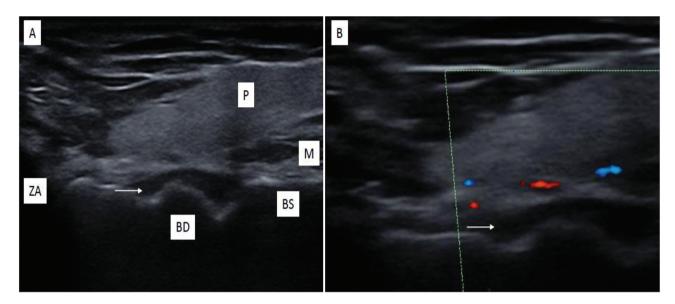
Ultrasound image of the right cheek region (cropped images). Cranial is to the left in both figures. (A) The overview shows the parotid gland (P) with the masseter muscle (M) below. The complete reflection of the ultrasound at the unaffected bone surface produces a linear pattern in the area below the defect, confirming a smooth bone surface (BS). Further cranially and in the former bone defect (BD), the reflection pattern of the bone surface becomes slightly wavy, indicating the uneven distribution of ultrasound-reflecting structures. The left edge of the image shows the acoustic shadow created by the zygomatic arch (ZA). (B) The Doppler function of ultrasound reveals vessels within the gland. The calcified region has no representation of vessels. In both images, a slightly arcuate, thin, hypodense region separates the muscle from the bone surface (Arrow in A and B). Such hypodense boundary layers are often observed in mandibular callus formation.
